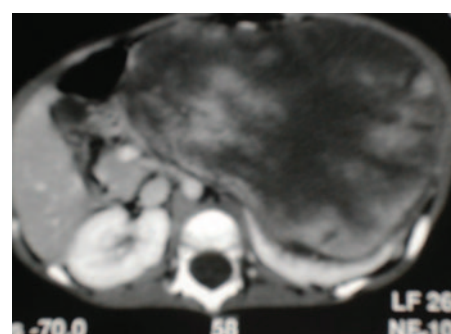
A computed tomography scan revealing a multi-septate tumour of the left kidney.
